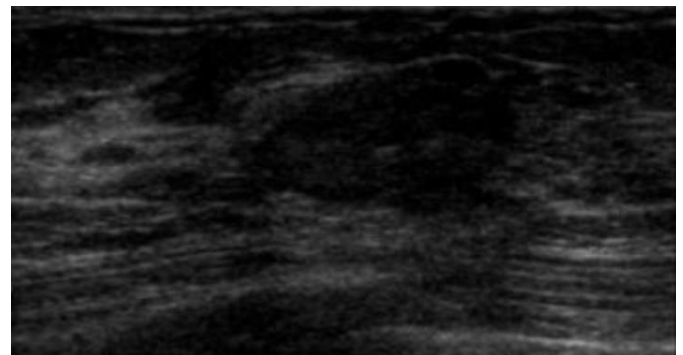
a) Breast Ultrasound Image
